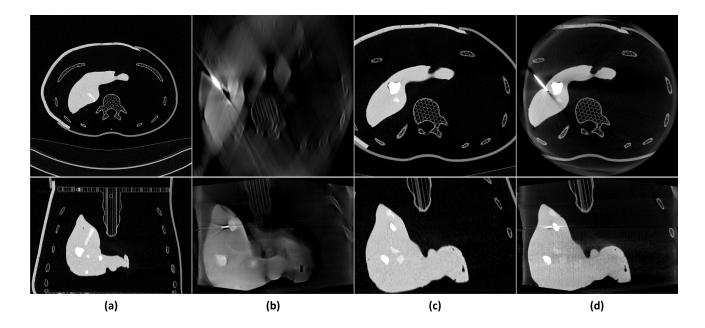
Registration results. (a) Prior CT, (b) intermediate intraoperative tomosynthesis, (c) coregistered prior CT, and (d) intraoperative CBCT. Upper row: one axial slice. Lower row: one coronal slice. Same slices are shown in (b), (c), and (d). The display window range is [-1000HU, 700HU].
